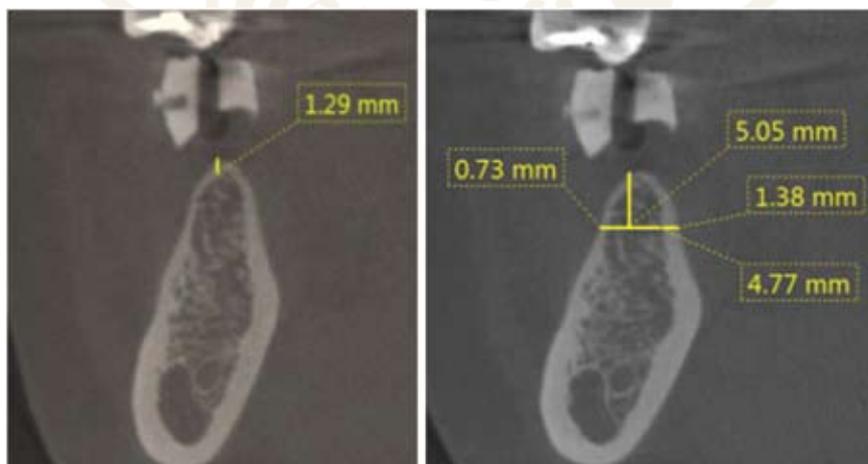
Crestal cortical thickness and buccolingual bone thickness measurement from CBCT
